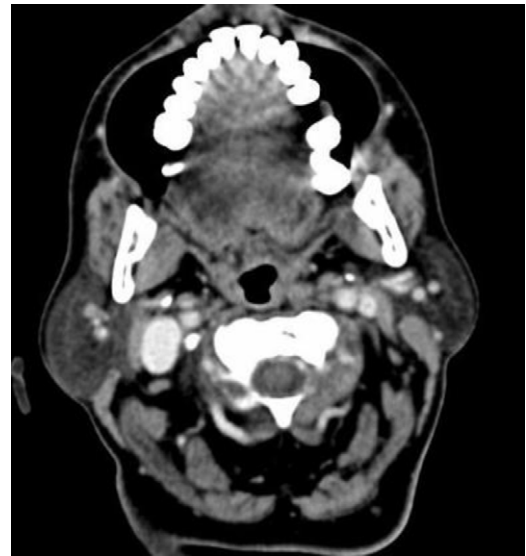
Axial CT image showing infiltrative pathology of left masseter muscle.
